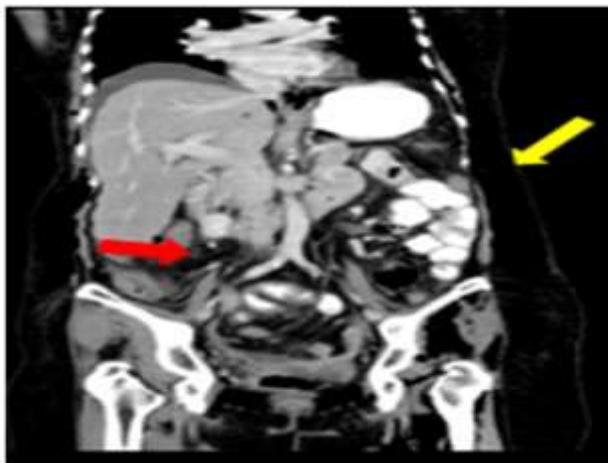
A coronal view of CT scan of the abdomen and chest showing generalized subcutaneous emphysema of abdominal wall (yellow arrow) and pneumoperitoneum (red arrow).
